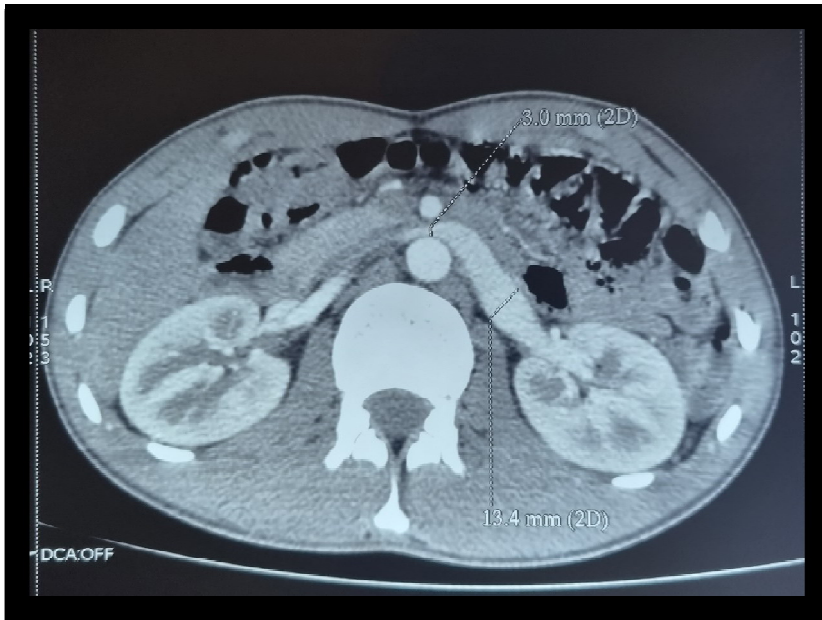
Axial section abdomino-pelvic CT scan before and after contrast material injection, beak sign (arrow) designating at the level of the aorto-mesenteric fork
